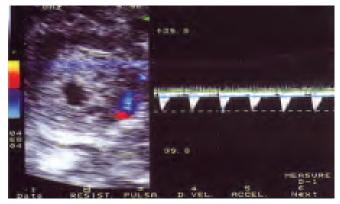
Gestational sac measuring 12 mm in the left adnexal region. Color Doppler depicts a small area of angiogenesis characterized by a high resistance index (RI = 0.73). This finding is indicative of tubal abortion
